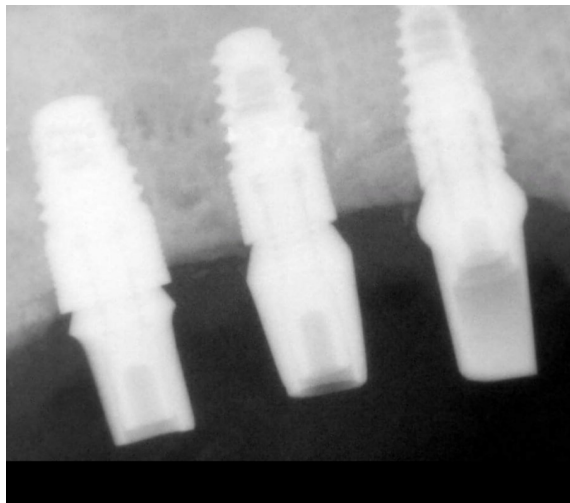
Intraoral radiographic image taken at time of loading.
